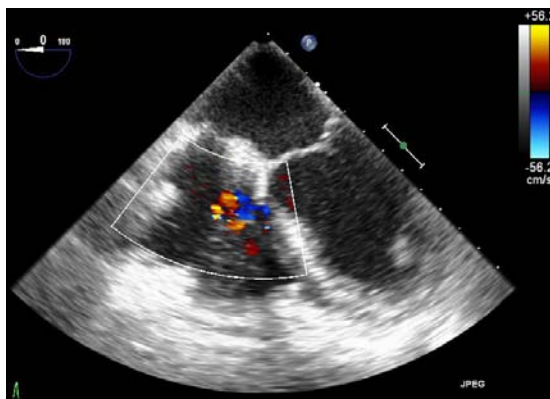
Trace tricuspid regurgitation on color flow Doppler (103)
